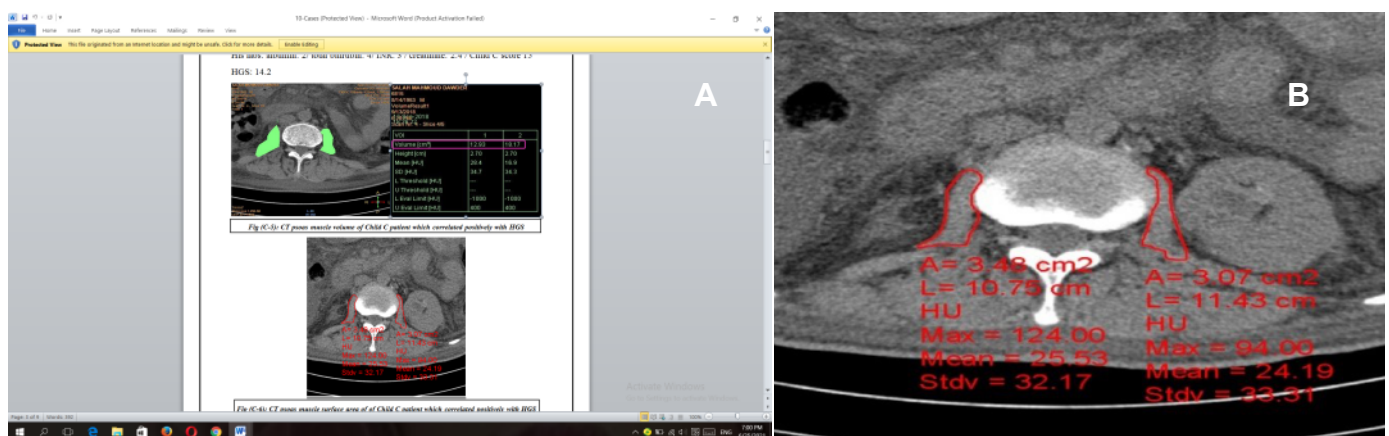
CT psoas volume (A) a surface area (B) of Child C patient
